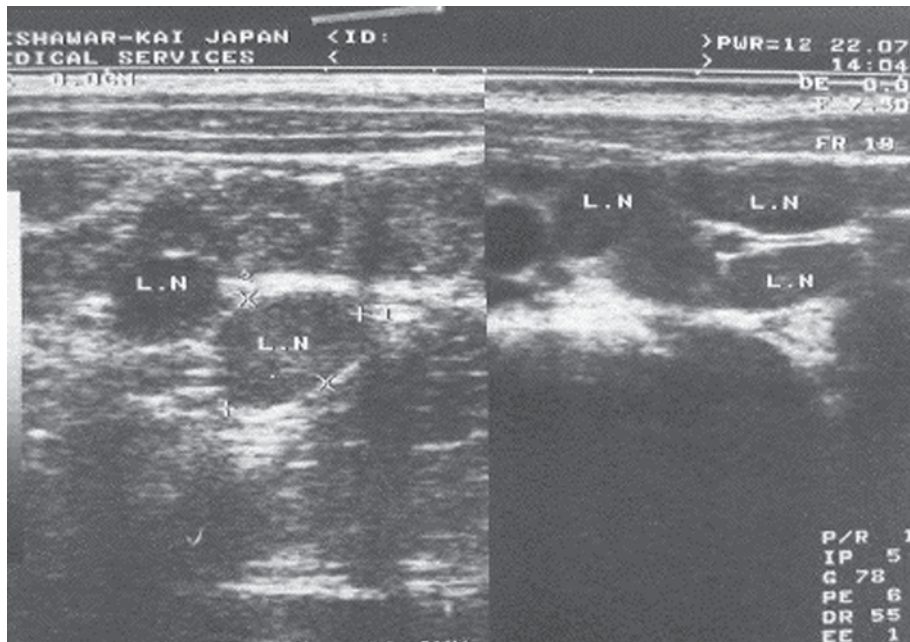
Ultrasonographic image of the culture-negative 10-year-old male case. Typical multiple mesenteric lymph node enlargements were seen. One of the largest measured 1.5 cm.
